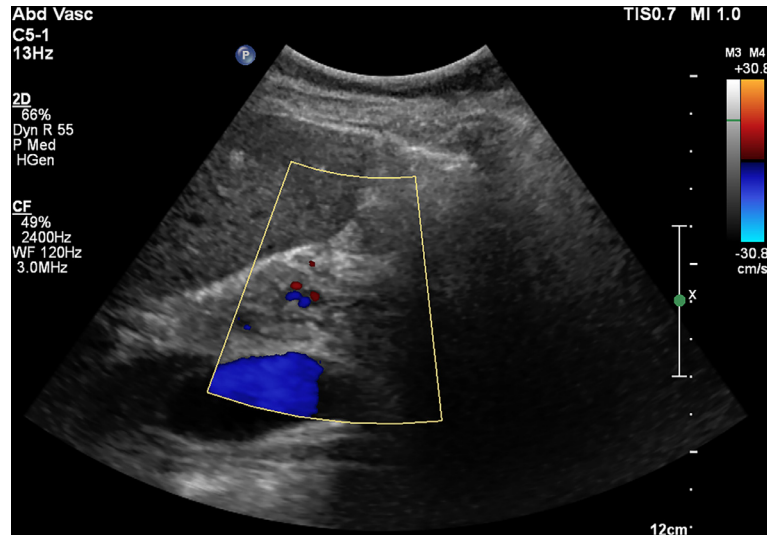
Abdominal ultrasound demonstrates a heterogenous porta-hepatis mass.
